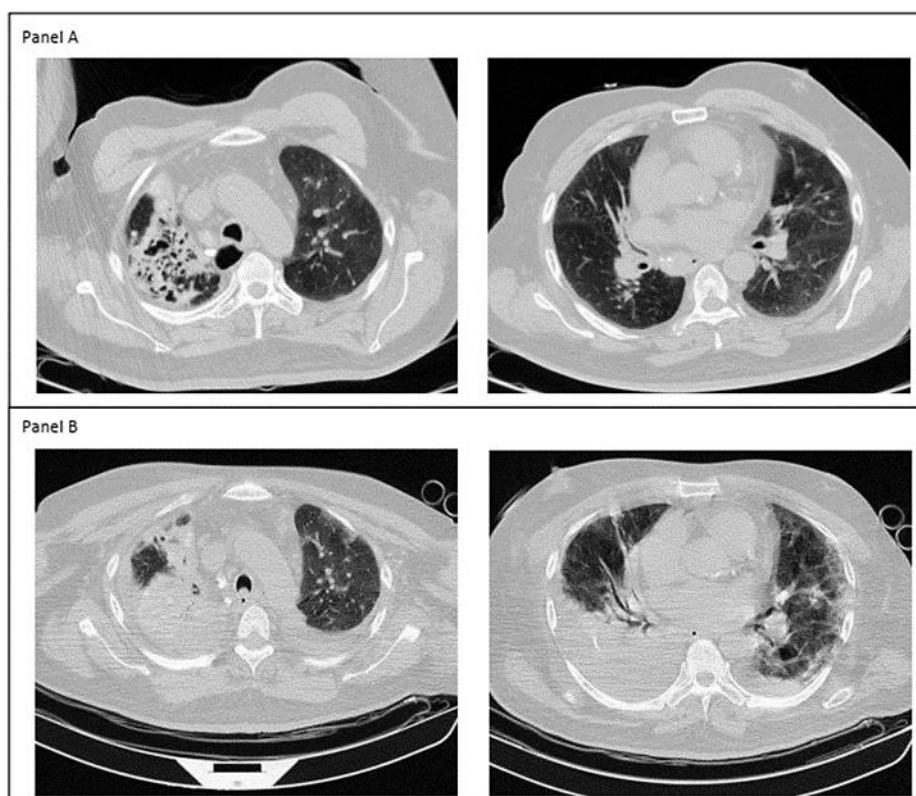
Second case lung chest CT scan on hospital day one and day 14
